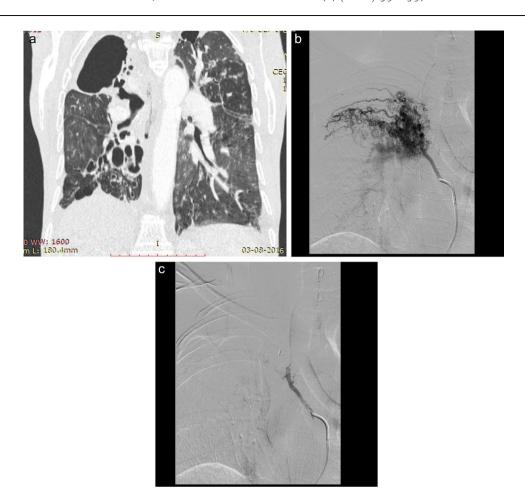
(a) CT scan image of a patient who presented with recurrent hemoptysis showing bronchiectasis and fibrotic changes in Rt lung with volume loss. (b) DSA done before BAE showed hypertrophied Rt Intercostobronchial trunk with significant abnormal vascular blush. (c) Post BAE DSA showing complete disappearance of abnormal vascular blush. Other feeders were also embolized in this patient (not shown here).
